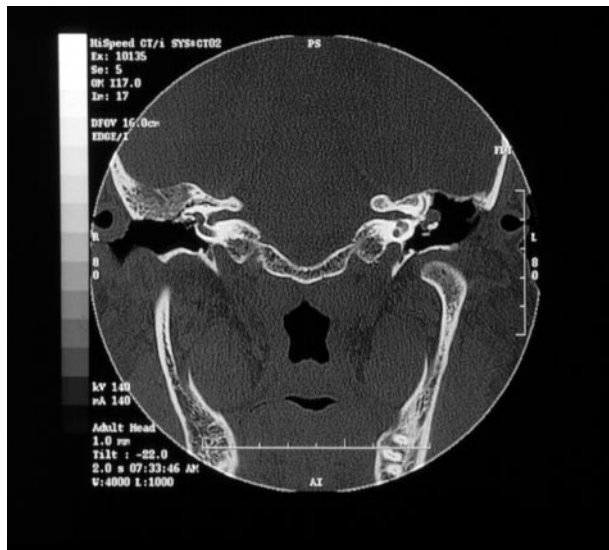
Axial computed tomographic scan showing inflammatory soft tissue (*arrow*) filling the right middle ear with a large fibrotic polyp extending into the external auditory canal and obscuring visualization of the tympanic membrane.
